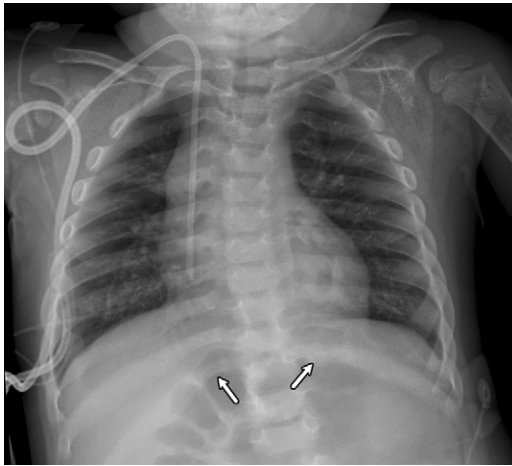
Thick ribs in a 5-year-old girl with Hurler syndrome. Frontal chest radiograph shows widening of the posterior ribs. The costal end of the inferior ribs is constricted (arrows), giving rise to a canoe-paddle appearance characteristic of mucopolysaccharidoses. A central venous catheter is in place for enzyme replacement therapy.
